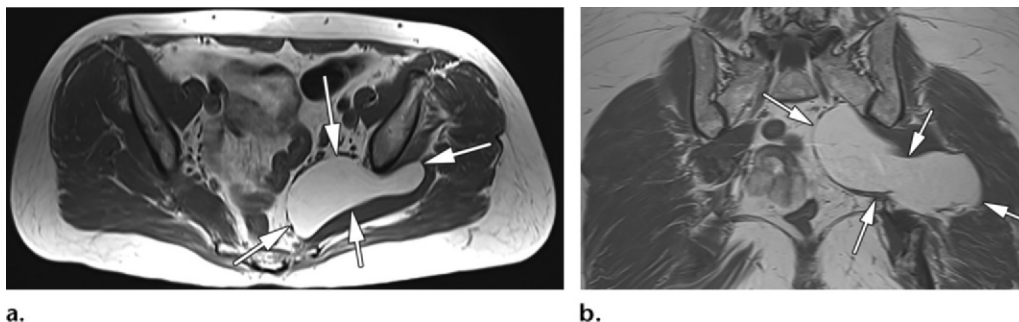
Deep lipoma of the pelvis in a 65-year-old woman. Axial (a) and coronal (b) T1-weighted MR images of the pelvis show a homogeneous fat-containing extraperitoneal mass (arrows) centered within the left pelvis. The mass is displacing the left piriformis muscle and the neurovascular structures. Note the presence of a thin capsule without nodularity or any nonadipose component.
